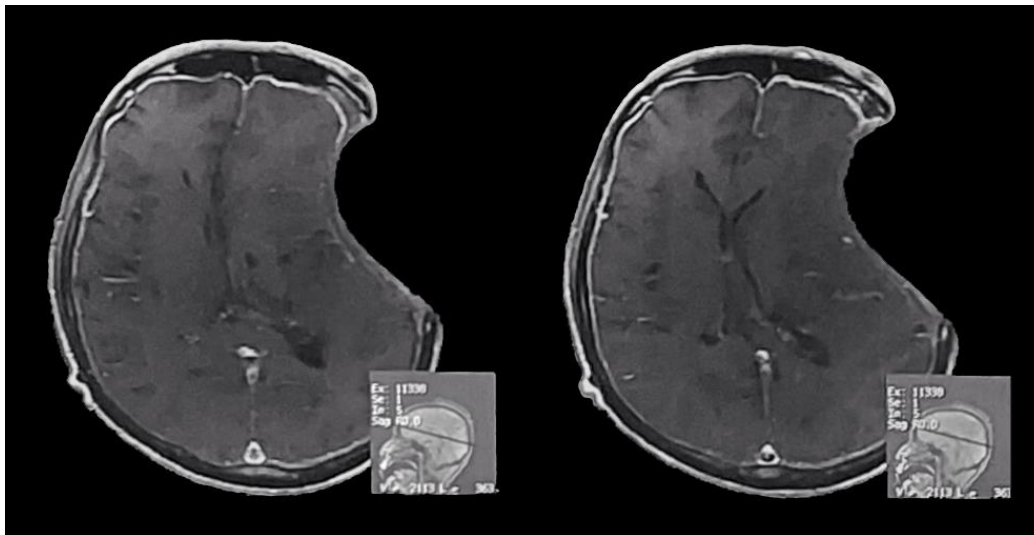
Head MRI showed bone defect in the left fronto-temporo-parietal region, perifocal oedema in the left centrum semiovale and left corona radiata and 1.5 cm midline shift to the right hemisphere
